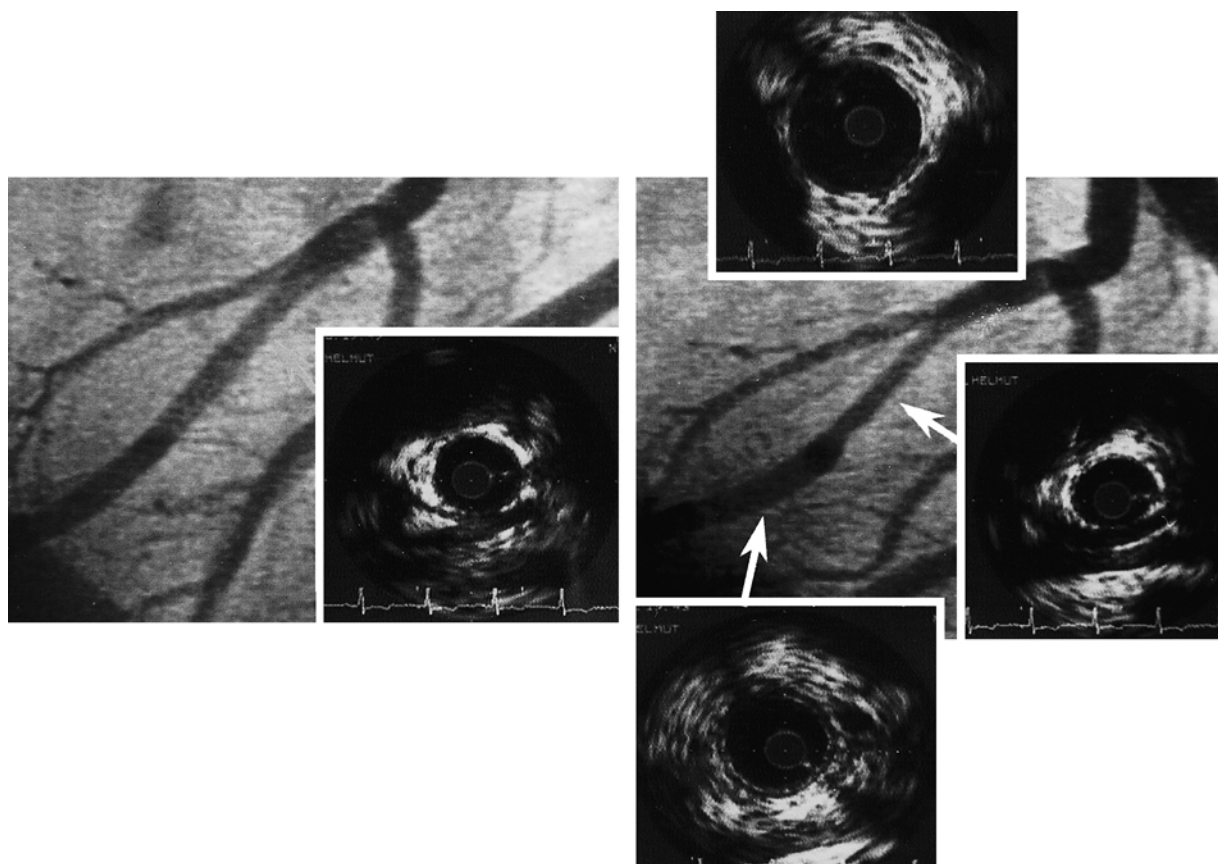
Coronary angiogram and intravascular ultrasound images of bridge segments during diastole and systole. The specific 'half moon' area can only be seen in the bridged segment. The half moon does not exist in the proximal and distal segment. The distance between two calibration marks is 1 mm.
